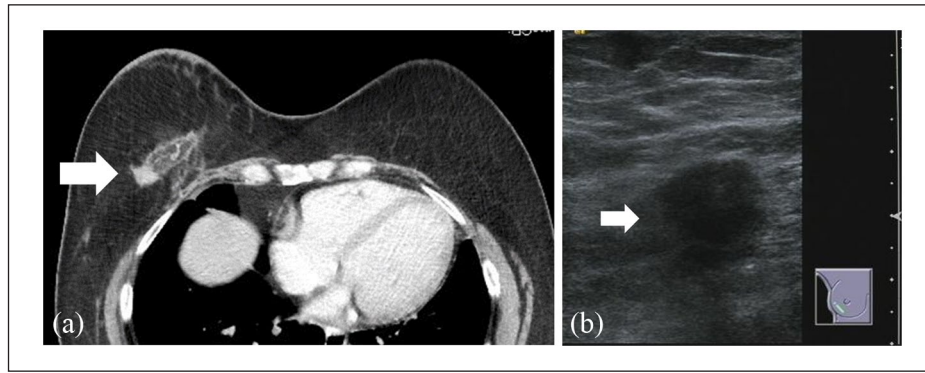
(a) Contrast-enhanced computed tomography shows enhanced solid mass lesions in the deep tissue in addition to the superficial tissue of the reconstructed breast. (b) Second-look ultrasonography shows the mass in deep adipose tissue of the reconstructed breast.
